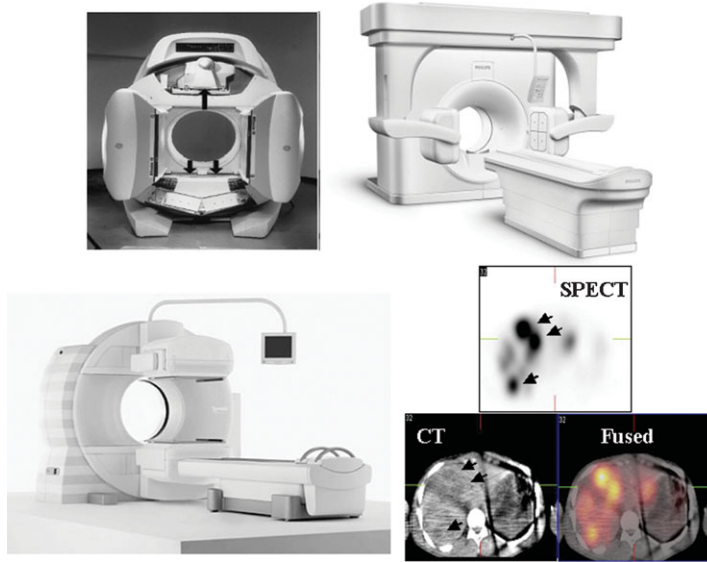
Commercial SPECT CT systems. These systems combine a CT system for anatomical information with a SPECT system. The devices shown are the GE Infinia Hawkeye, Philips Precedence, and Siemens Symbia. The lower right image shows an example of an ^{111}In Pentetreotide study in a patient with carcinoid along with co-registered CT images.
